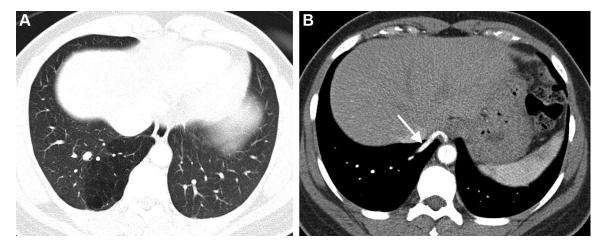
A, Axial CT image on lung windows in a 45-y-old asymptomatic woman showing focal air trapping and mild cystic changes in the medial and posterior basilar segments of the right lower lobe. B, Axial contrast-enhanced CT image on mediastinal windows in the same patient showing aberrant arterial supply from the distal descending thoracic aorta consistent with bronchopulmonary sequestration (arrow).
